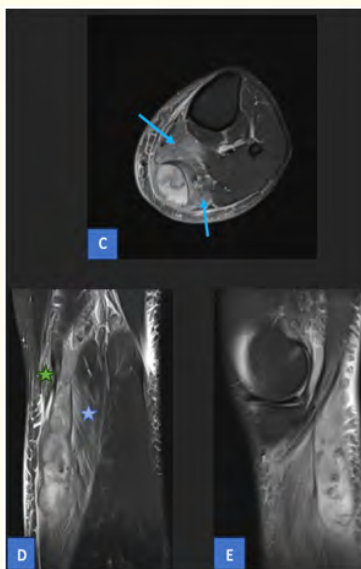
Axial (A, B, C) coronal (D) and sagittal (E) MRI sequences of the right knee demonstrating a ruptured popliteal cyst with hematoma. T1-weighted image showing a well-defined, hypointense mass in the posterior intercondylar region (yellow arrow). T2-weighted image displaying relative hypointensity, reflecting the hemorrhagic and organized nature of the cyst content (red arrow). STIR sequence highlighting surrounding edema (blue arrow) and the extension of the hematoma between the gastrocnemius (blue asterisk) and semimembranosus (green asterisk) muscles, consistent with a ruptured hemorrhagic popliteal cyst.
